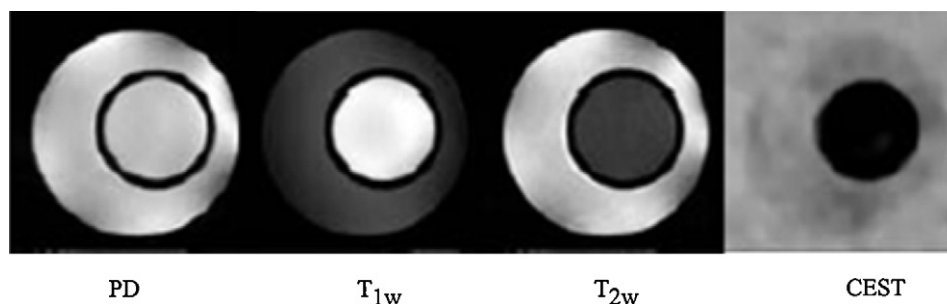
MR images (7 T, 312 K) of a capillary, dipped into neat water, containing a suspension of an osmotically shrunken Gd-based liposome. From left to right: Proton density image, T_{1w} image, T_{2w} image, and CEST difference image ($\nu_7 - \nu_{-7}$, saturation scheme: 2 s single cw pulse, B_2 intensity 6 μT). Adapted from ref. [96].
